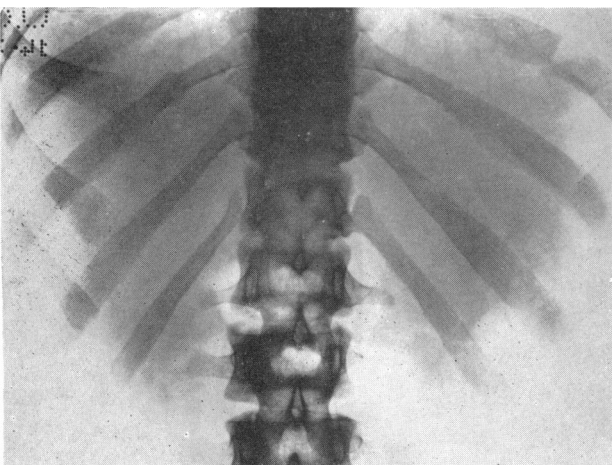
Radiograph of lower ribs on March 14, 1955, showing laying down of callus and calcification of Looser's zones after treatment for ten weeks.
